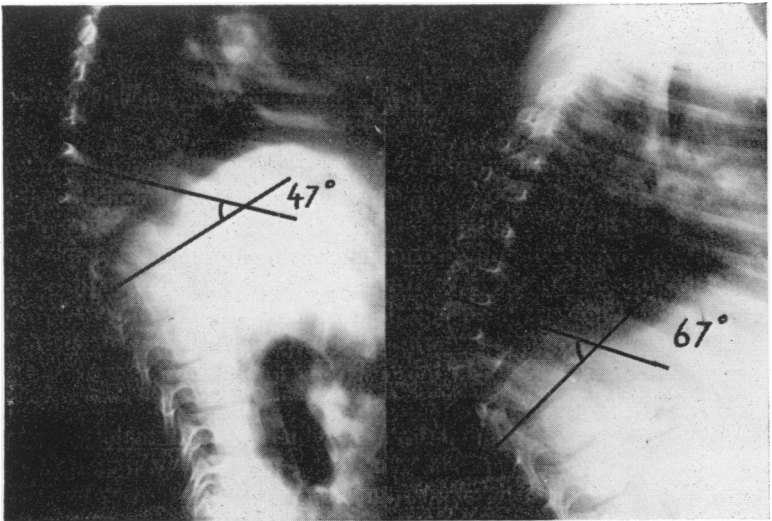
X-rays showing angulation.
